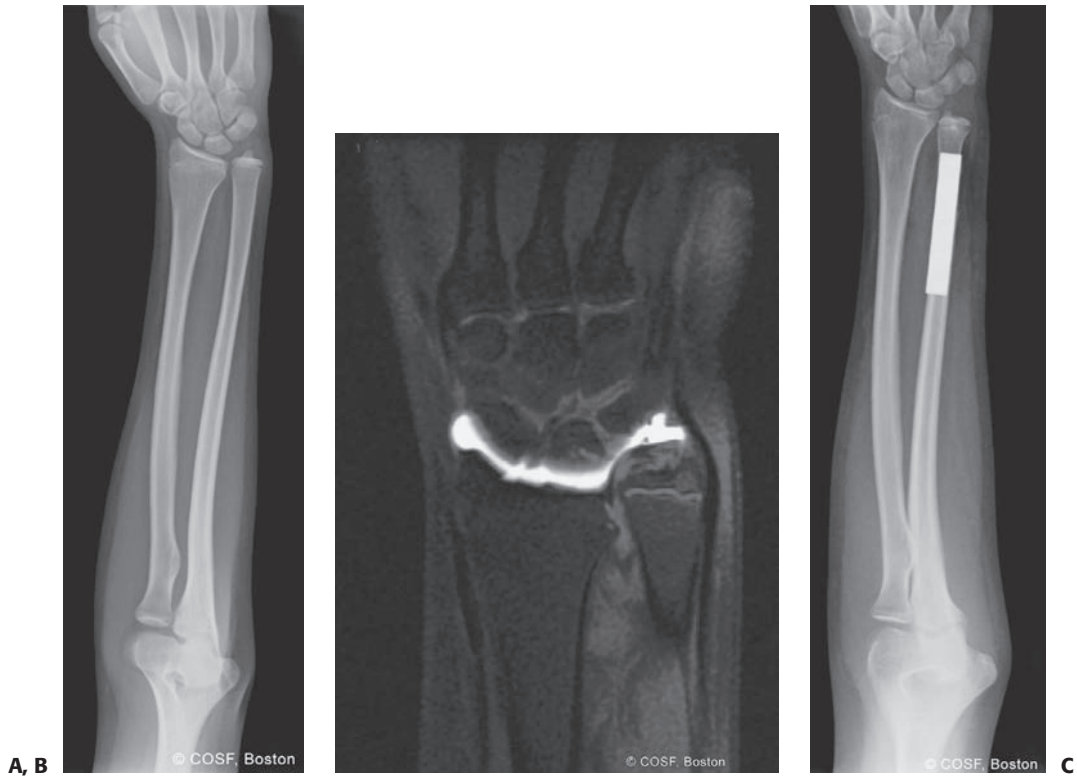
A: AP radiograph of growth arrest with open ulnar physis. B: MRI scan of large area of growth arrest that was not deemed respectable by mapping. Note is made of impaction of the distal ulna against the triquetrum and a secondary peripheral TFCC tear. C: Radiograph after ulnar shortening osteotomy, restoring neutral ulnar variance.
